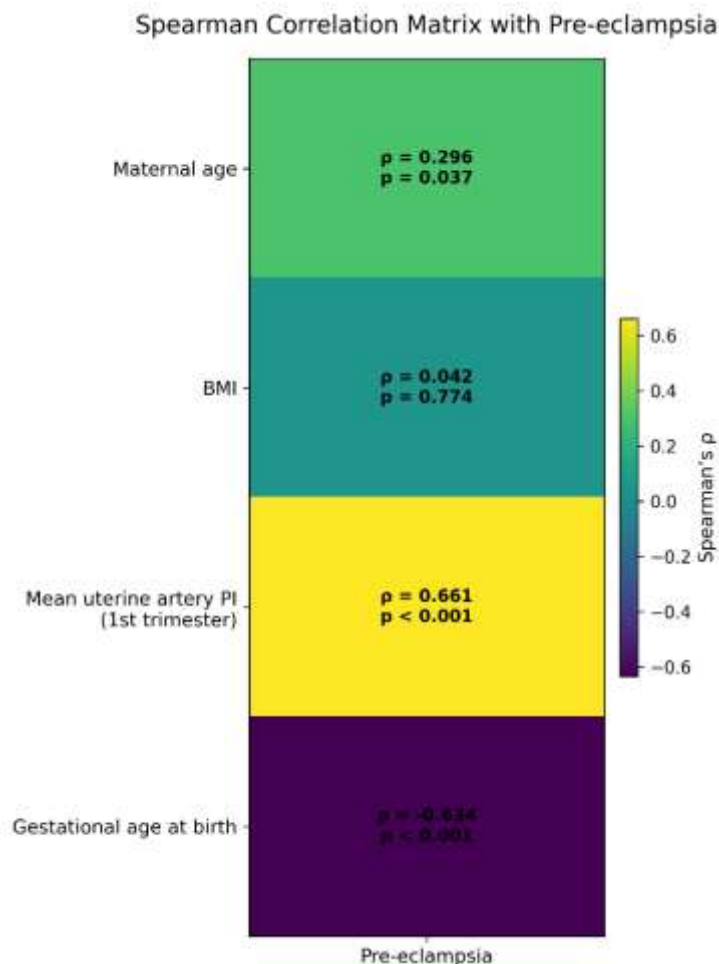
Spearman correlation matrix between maternal characteristics, Doppler parameters, and pre-eclampsia.
